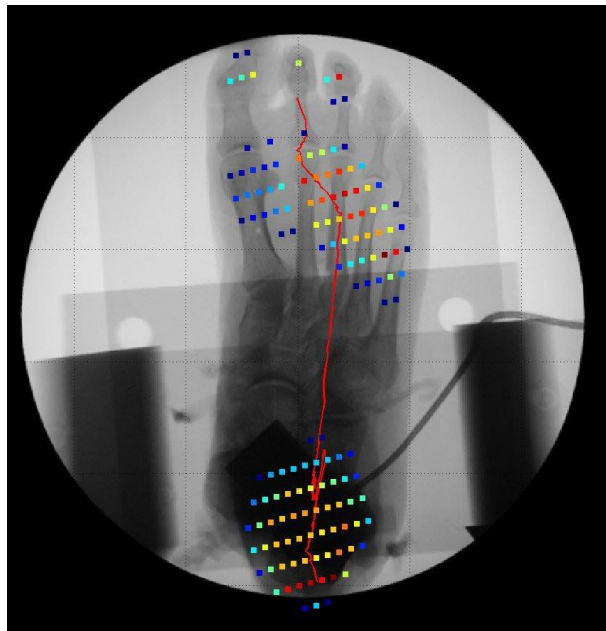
Plantar pressure data registered to a radiograph.
